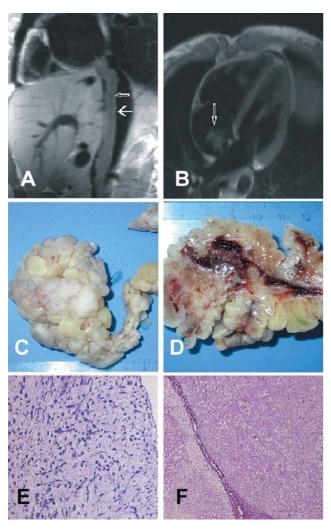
A: Sagittal magnetic resonance imaging (MRI) of the thorax reveals the long distance thrombus.
